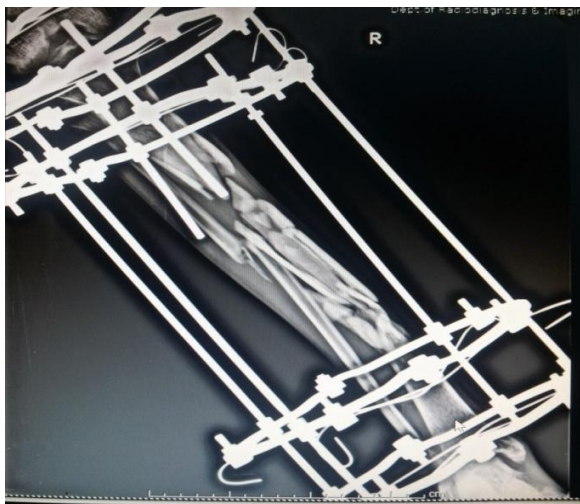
comminuted and segmental tibia # follow up x-rays
